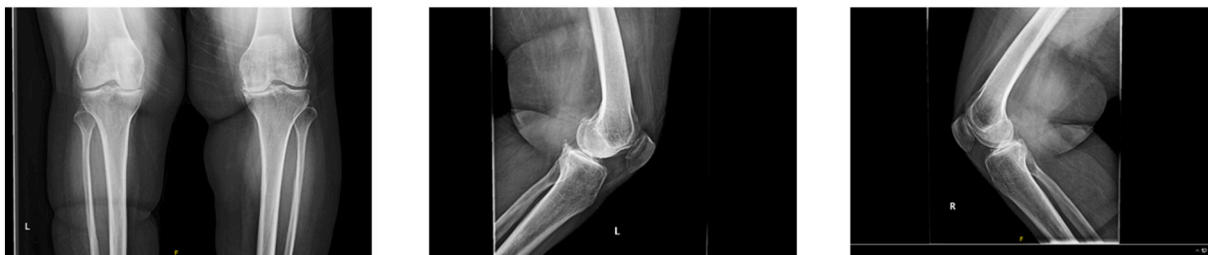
Bilateral knees standing AP and lateral radiographs during first visit in clinic.
